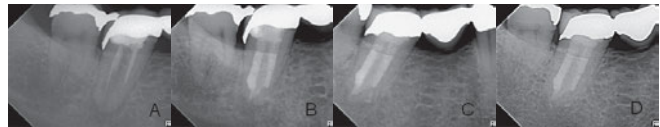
Radiographic control: preoperative situation (A), obturation (B), one year after treatment (C), four years after treatment (D). This case was apically obturated using MTA.
